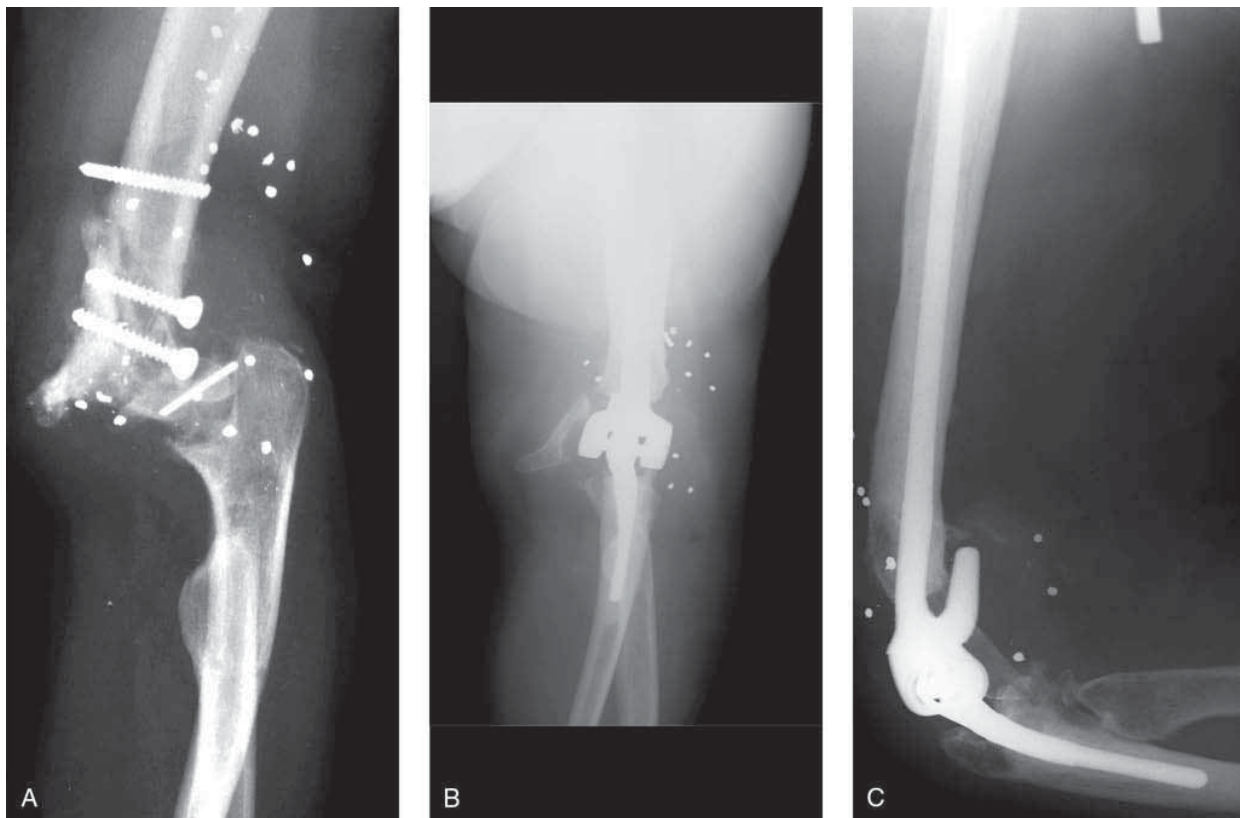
A, Radiograph showing gross deformity of the elbow 3 years after the repair of a gunshot wound. Radiographs of the elbow 9 years after arthroplasty using a semiconstrained linked prosthesis showing that the bushings have not worn (B) and both ulnar and humeral components are well fixed (C). The bone graft has matured behind the flange.
